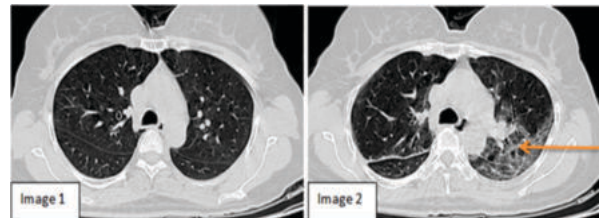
Axial HRCT Thorax Images of 37 old female Patient Image 1: On day 1, Minimal changes noted on HRCT (CRP - 9, CT Severity score-0). Image 2: On day 10, GGOs opacities in left posterior segment of upper lobe and apical segment of Lower lobe (Arrow) (CRP-23, CT severity score-10) (WL:-450, WW:1500)
